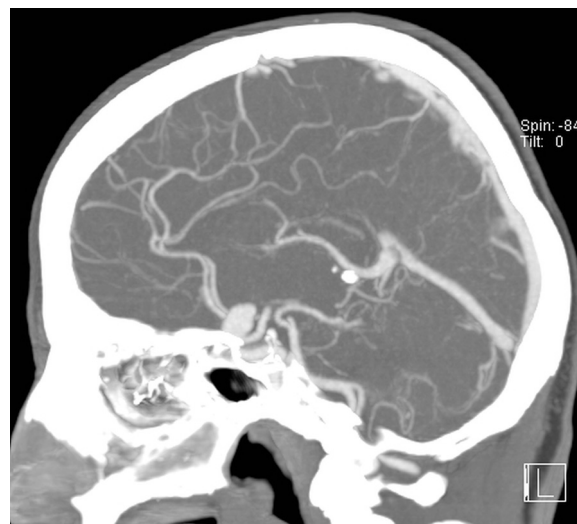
Initial CT angiography: there is a saccular aneurysm near the tip of the carotid artery on the left.
